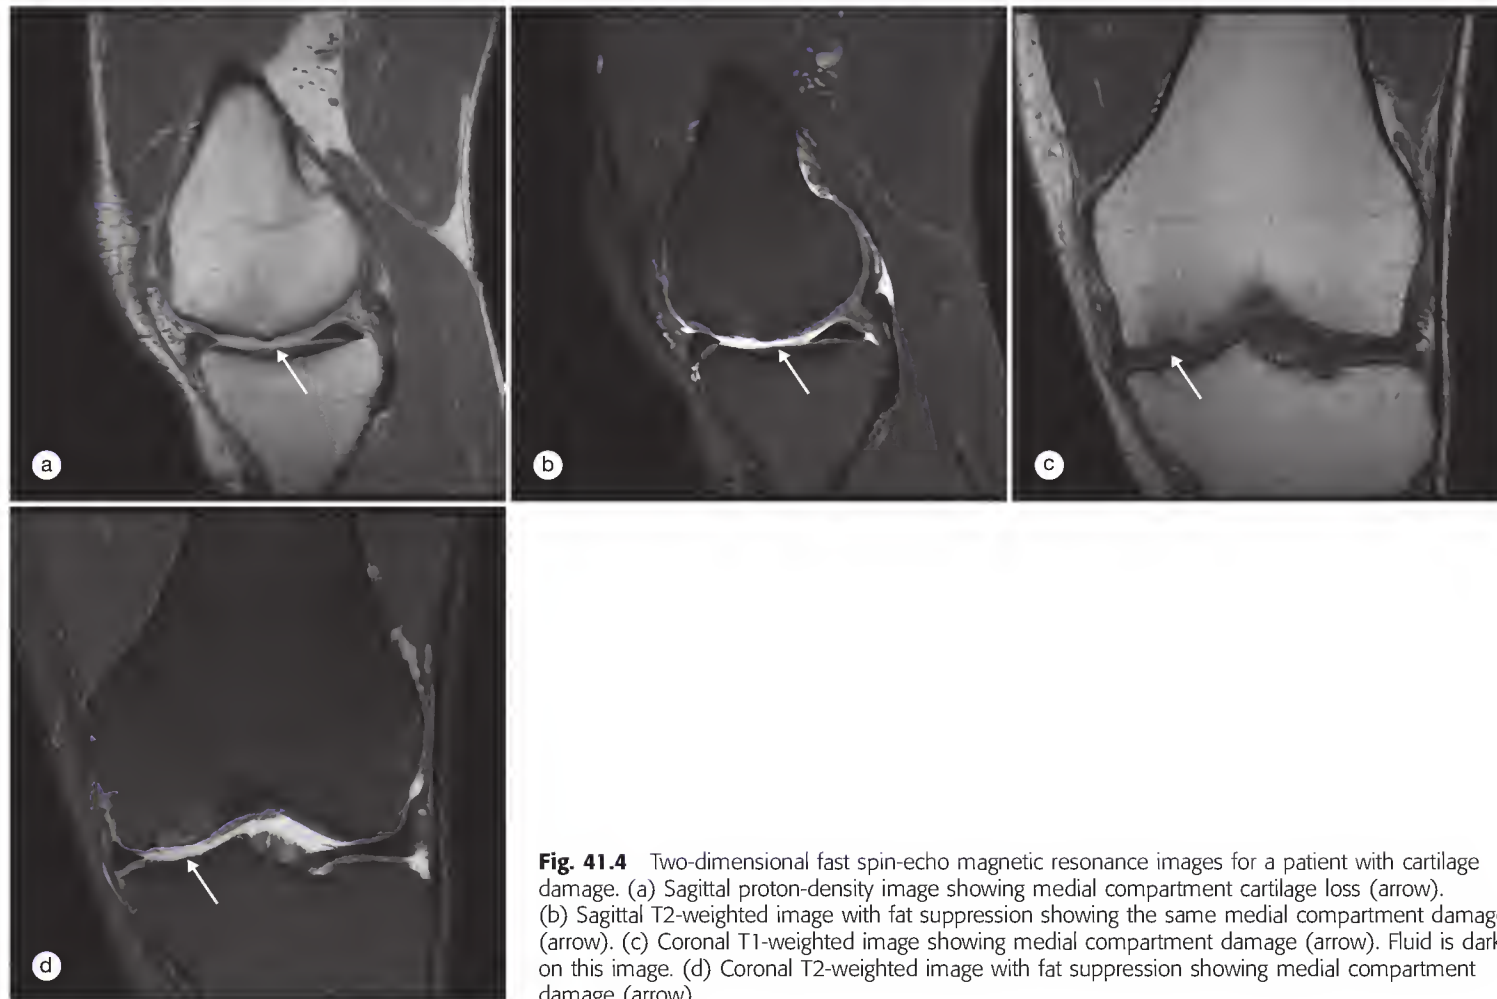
Two-dimensional fast spin-echo magnetic resonance images for a patient with cartilage damage. (a) Sagittal proton-density image showing medial compartment cartilage loss (arrow). (b) Sagittal T2-weighted image with fat suppression showing the same medial compartment damage (arrow). (c) Coronal T1-weighted image showing medial compartment damage (arrow). Fluid is dark on this image. (d) Coronal T2-weighted image with fat suppression showing medial compartment damage (arrow).
